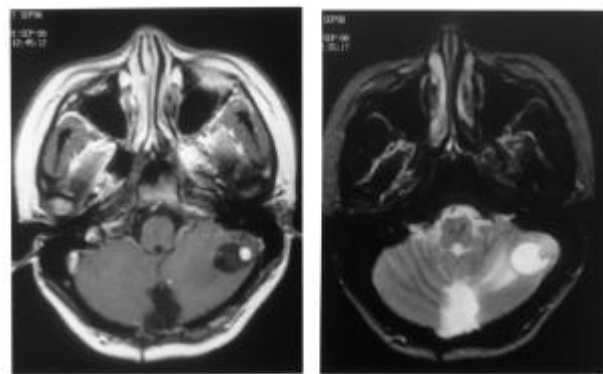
Brain-magnetic resonance imaging (MRI), three months before pregnancy. A) T2 not enhanced B) T1 postgadolinium enhanced, showing the largest hemangioblastoma with 1.8-cm cyst in the left cerebellar hemisphere.
